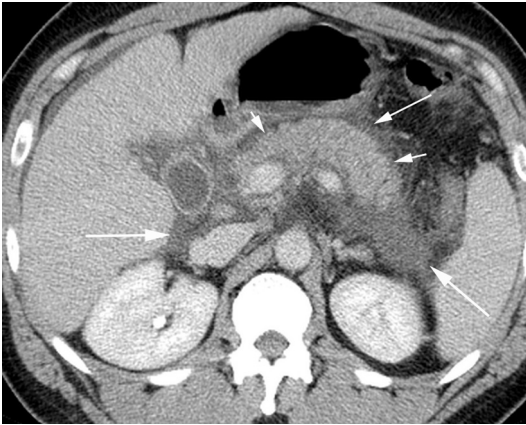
Acute interstitial edematous pancreatitis with multiple fluid collections, CTSI 4. CT image in the axial plane of a 22-year-old man demonstrates an edematous pancreas (*short arrows*), and multiple fluid collections (APFCs) (*long white arrows*) are present anterior to the pancreas and in both anterior pararenal spaces.
